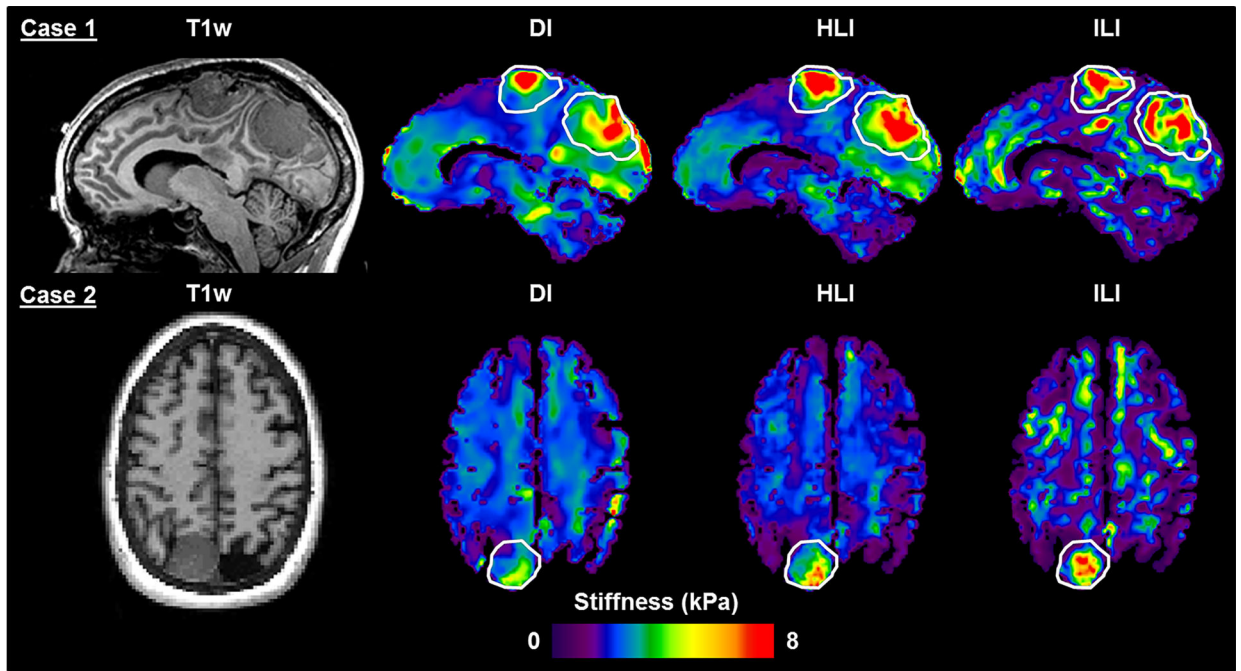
T1-weighted image and inversion results in two meningioma cases.
